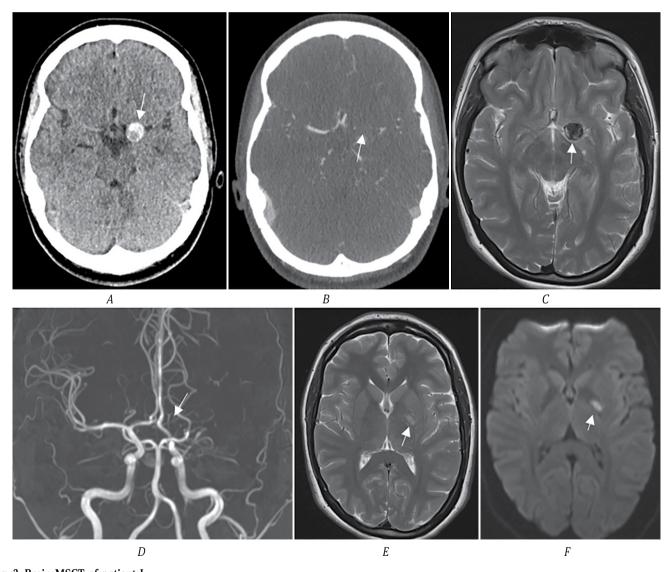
Brain MSCT of patient I. *A,* TA is indicated with the arrow; *B,* MSCT angiography, the white arrow indicates no blood flow in the left MCA; *C,* T2-WI MRI, the arrow indicates MCA TA; *D,* MR angiography, no blood flow in the left MCA (shown with the arrow); *E, F,* T2-WI and DWI, an ischemic lesion in the internal capsule is shown with the arrow.
